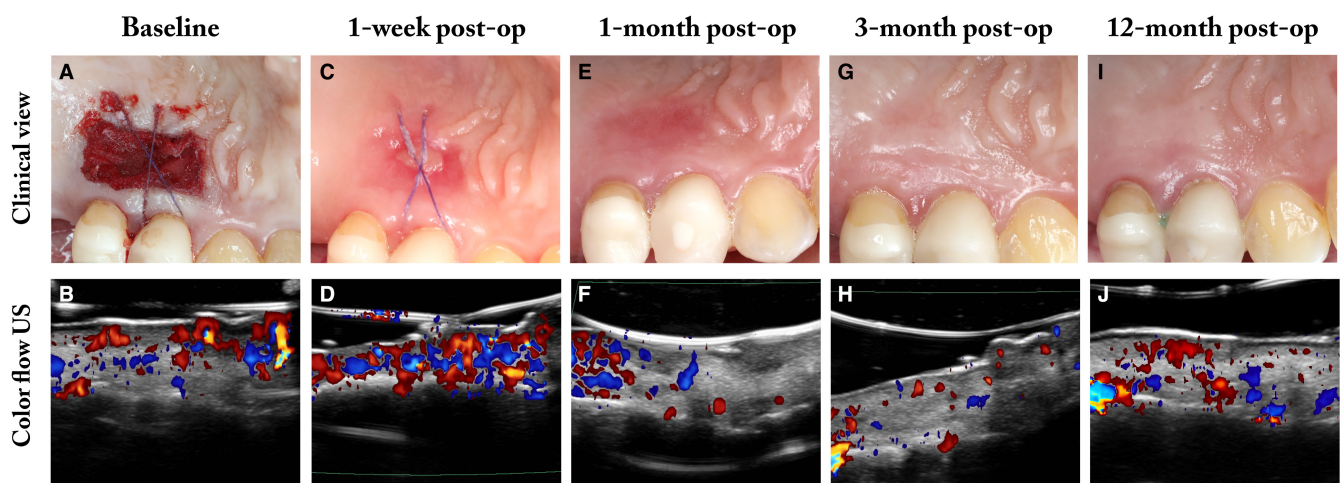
Temporary palatal sensory dysfunction following palatal harvesting. A, B, Baseline clinical view and ultrasound (US) scan. C, D, Clinical view and ultrasound scan 1 week after the surgery. The patient did not report any concern at this follow-up visit. E, F, Clinical view and ultrasound scan 1 month after the surgery. The patient complained regarding a sensory dysfunction in the anterior area of the palate, in the proximity of the canine and palatine rugae. The ultrasound scan showed an abnormal vascularization of the area with no blood flow visible in the anterior palate. G, H, Clinical view and ultrasound scan 3 months after the surgery. The patient reported that the sensory dysfunction of the anterior palate was completely resolved. The ultrasound scan showed a more uniform blood flow in the palate. I, J, Clinical view and ultrasound scan 12 months after the harvesting. It is possible to appreciate a uniform tissue perfusion of the donor site
